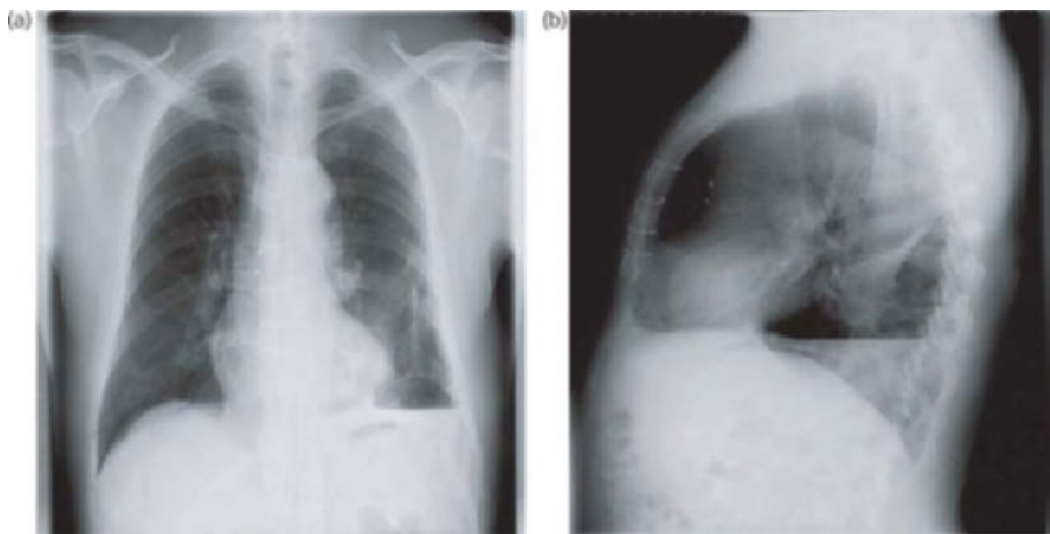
Roentgenological exam after induction of an artificial pneumothorax. The posteroanterior view reveals a small pneumothorax laterally (a) (arrow). The left upper lobe seems completely adhesive to the thoracic wall. The lateral view shows both the hydropneumothorax (b) (small arrow) posteriorly, and the adhesion (large arrow). The fifth intercostal space in the posterior axillary line was chosen as the point of entry for thoracoscopy.
